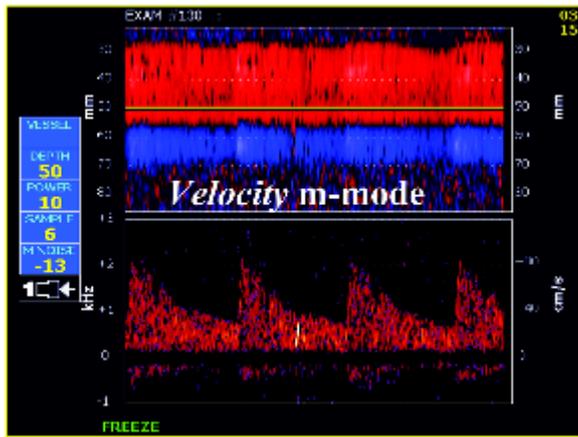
Simultaneous recording of the Doppler velocity m-mode and Doppler power m-mode with the corresponding single-gate transcranial Doppler spectrogram. In both the upper and lower panels, the single-gate spectrogram demonstrates a microembolic signal. The embolus is not seen in the velocity m-mode (upper panel) because it is moving with the same velocity as the blood. The embolus is clearly represented in the power m-mode (lower panel) as a sloping embolic track. Please see the text for further explanation.
